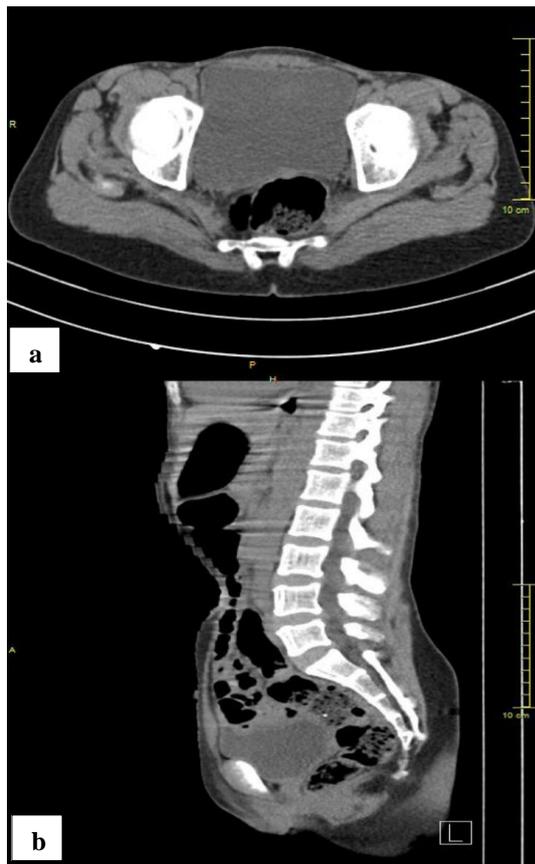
Abdominal and pelvic CT (a) sagittal reconstruction, and (b) axial section.
